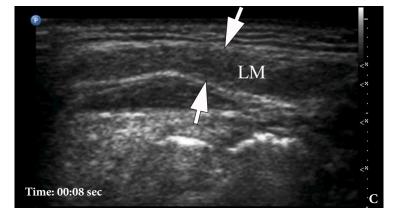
Longitudinal gray-scale ultrasound (i.e., B-mode ultrasound) of a lymphatic malformation (LM) demonstrates a well-circumscribed lesion in a slightly compressed state. *Open arrow* indicates larger cystic cavity and *open arrowhead* labels smaller cystic cavity inside the malformation. The LM measured 3.09 cm x 1.03 cm (indicated by "+" and "x" calipers). The depth of the ultrasound-scanned tissues is 3 cm, as indicated by the vertical scale with marks on the right.
